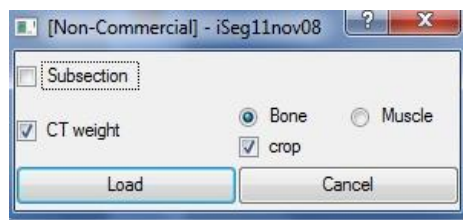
Pop up window after loading a DICOM image in *iSeg*. Selecting “CT weight”, “Bone,” and “crop”.
